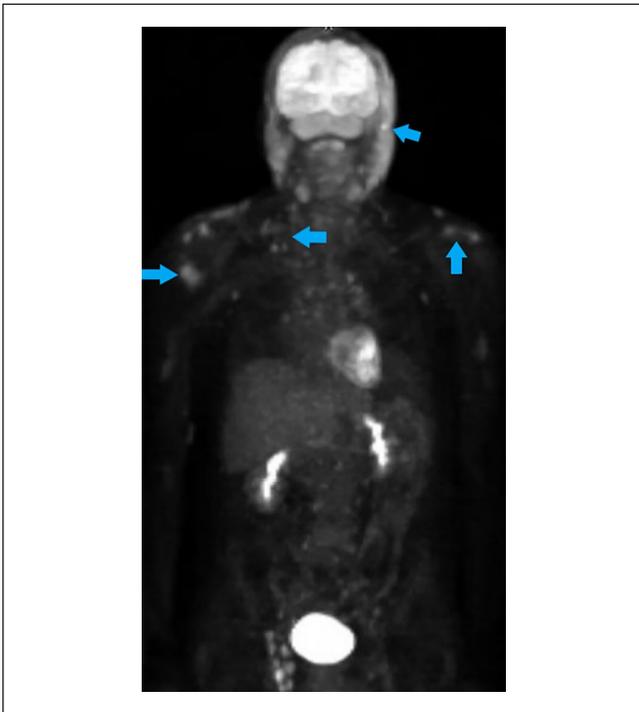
Positron emission tomography-computed tomography scan showing areas of skin thickening on the face, scalp, neck, upper chest, and shoulders (blue arrows). No other areas of abnormal uptake is observed.
